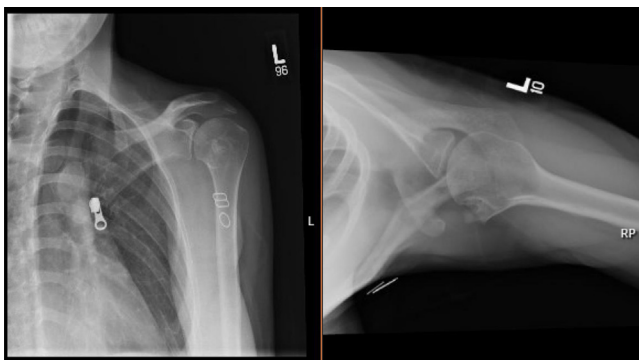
Nine-month postoperative anteroposterior and axillary radiographs demonstrating normal anatomic positioning.
